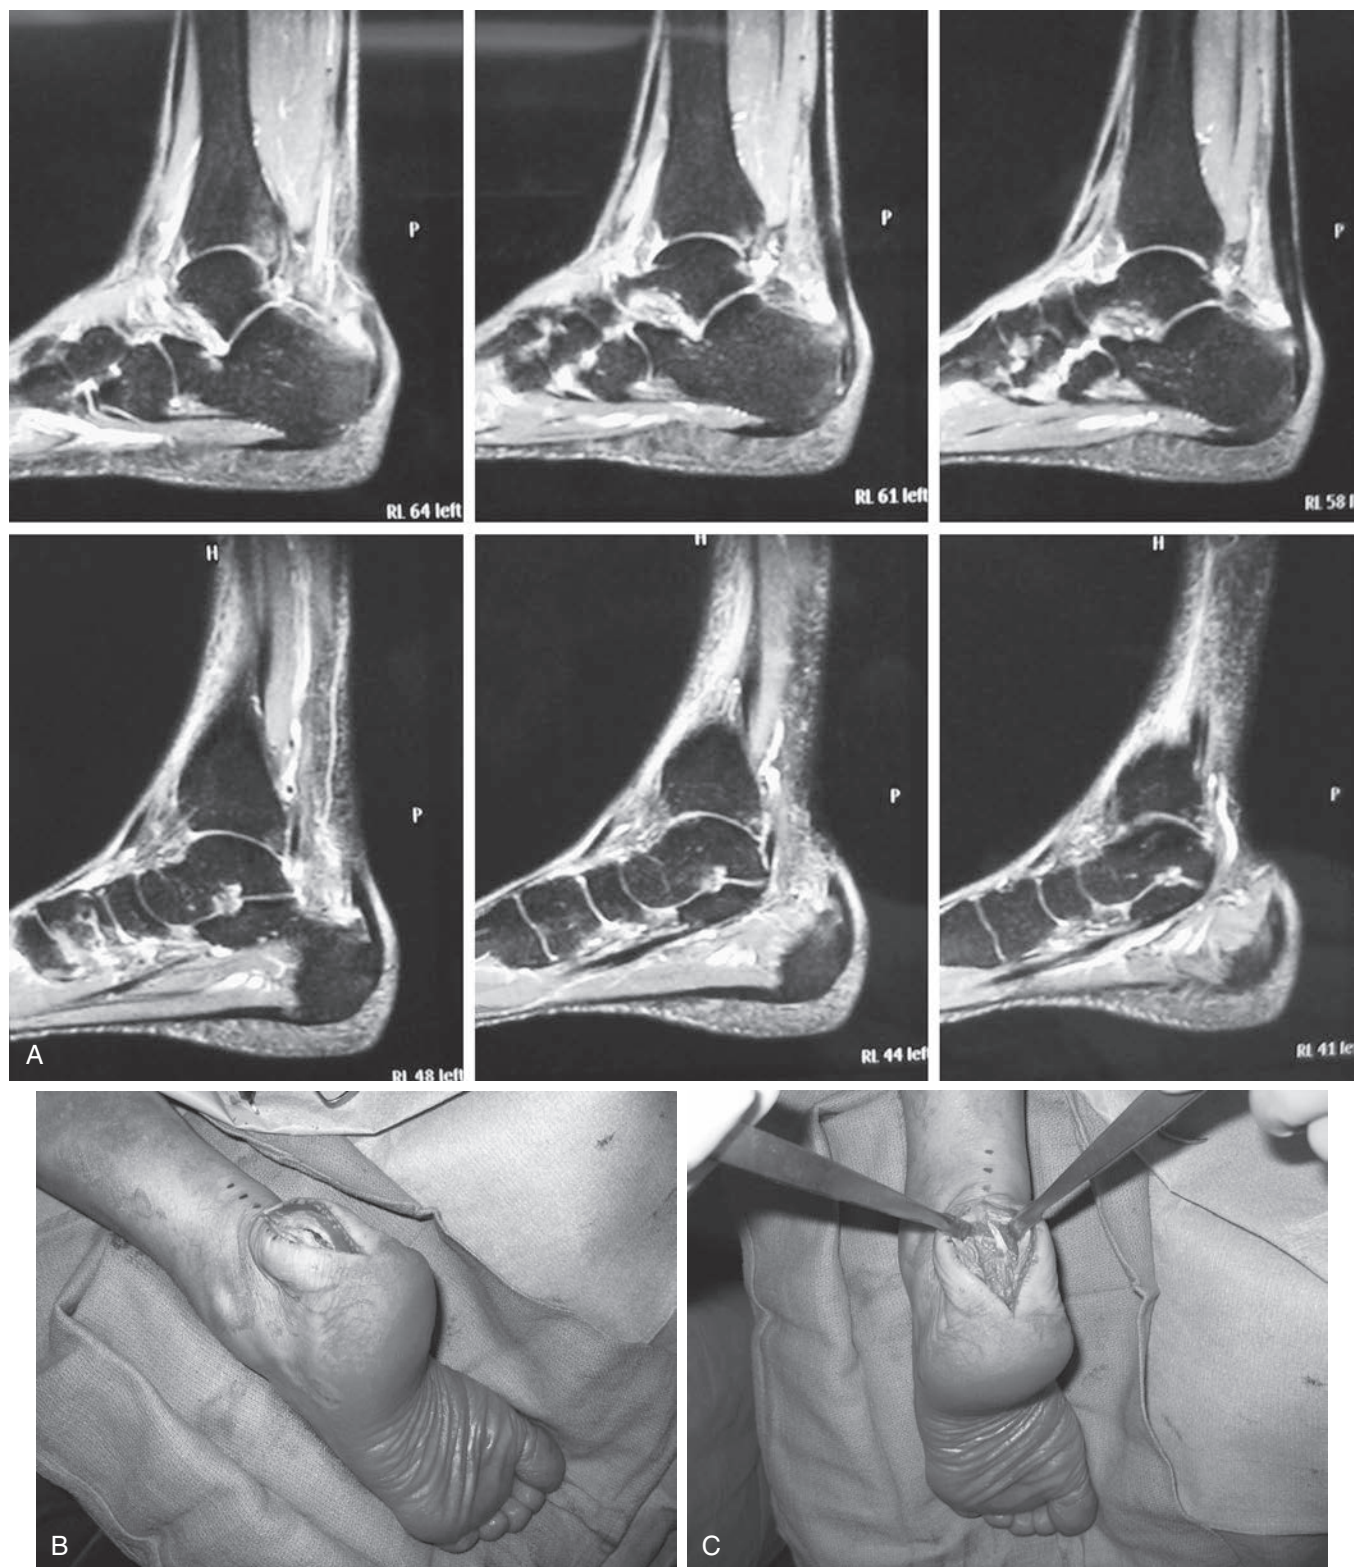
Insertional Achilles Tendinopathy. (A) Sagittal magnetic resonance imaging of a patient with insertional Achilles tendinopathy and retrocalcaneal bursitis. Note the bony prominence, the fluid in the bursa anterior to the tendon, and the abnormal signal at the insertion consistent with degeneration at the interface. (B) A central incision is made through the site of maximal tenderness through the tendon down to the bone. (C) The tendon is released from its insertion posteriorly and the posterior superior calcaneus is exposed.
